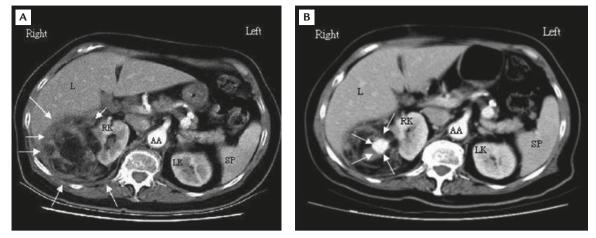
Contrast-enhanced abdominal CT scans before and after the episode of paradoxical CO_2 embolism. (A) Huge angiomyolipoma (arrows), measuring 11.9×8.6 cm, of the right kidney (RK) confined to the perirenal space. (B) Postoperatively, the same cutting level as Figure 2A shows possible pseudoaneurysm formation (arrows), enhanced brightly by contrast media, inside the tumor. LK = left kidney; SP = spleen; AA = abdominal aorta; L = liver.
